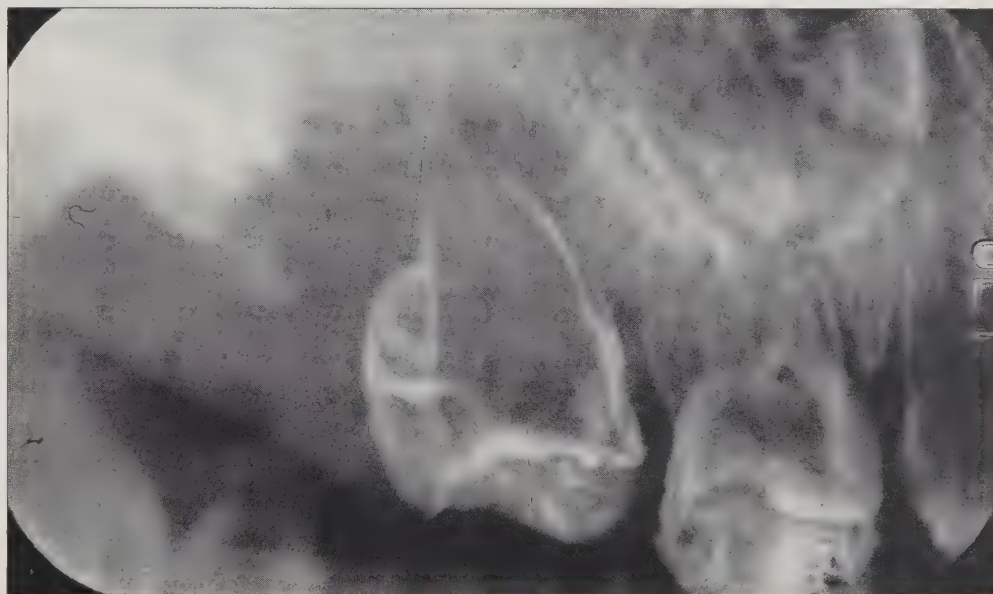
Upper right periapical view displaying "ghost" teeth 54 and 55.
